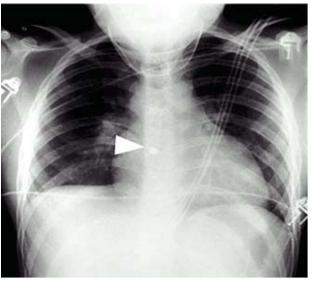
Chest radiography: a bullet in the heart
